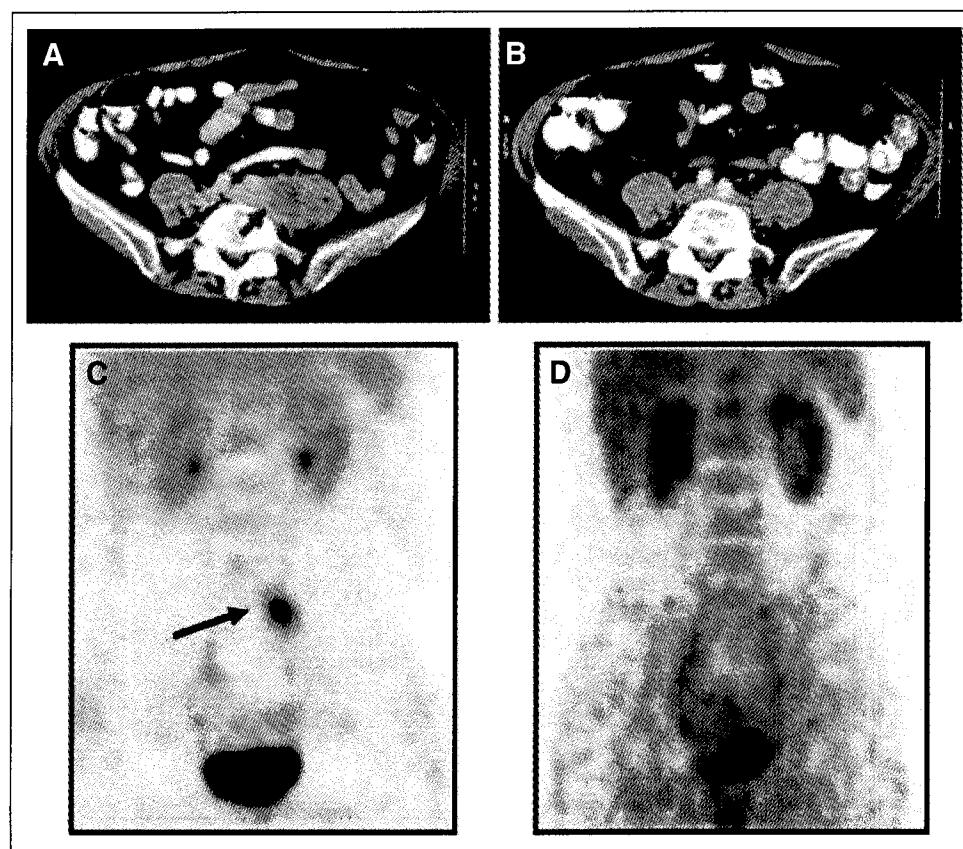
Tumor response to CP-870,893. (A, B) Radiographic evidence for objective partial response in patient 1017 and (C, D) fluorodeoxyglucose positron emission tomography images in same patient. (A, C) baseline; (B, D) after six doses of CP-870,893. Red arrow, metastatic disease at baseline; black arrow, abnormal tracer activity of tumor at baseline.
